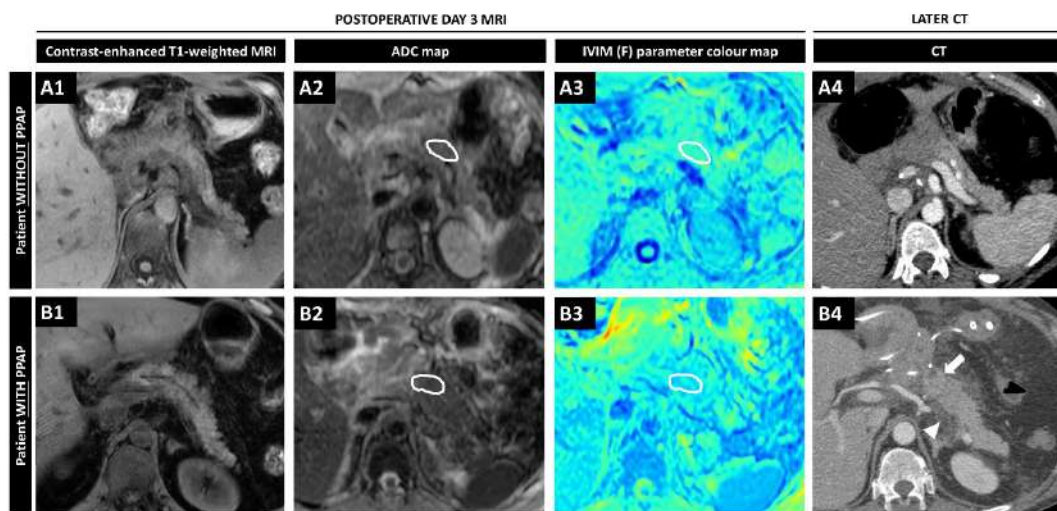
Contrast-enhanced T1-weighted MRI (1), ADC map (2), and IVIM (F) parameter colour map (3) with ROIs containing the pancreatic stump, and postoperative CT (4) images of patients without PPAP (A: Patient with an uneventful postoperative course and a CT scan performed on POD 8), and with PPAP (B: Patient with grade C PPAP. CT scan performed on POD 7 showing pancreatic parenchymal enlargement affecting the pancreatic stump and body [white arrow], with decreased attenuation and extensive stranding of retroperitoneal and intraperitoneal fat [white indicator]).
